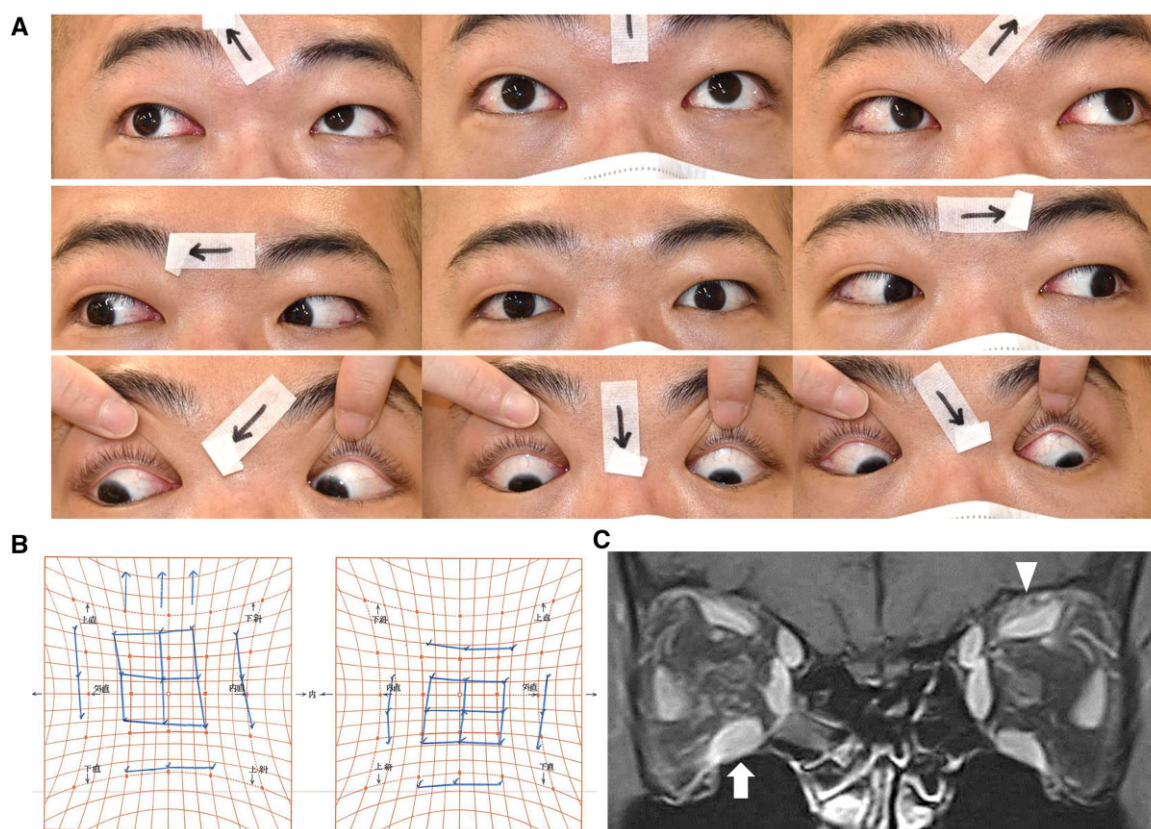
Ocular motility photographs (A) in nine gaze positions and Hess screen test (B) demonstrate mild restriction of the upward movement of the right eye. Magnetic resonance imaging of the orbits (C) shows an enlarged right inferior rectus muscle (arrow) and a high intensity around the left superior rectus muscle (arrowhead).
